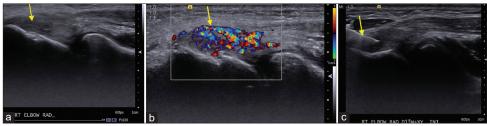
A 32-year-old male patient complaining of the right lateral elbow pain for approximately 1 month, (a) ultrasound showed uneven hypoechogenicity from the extensor digitorum tendon to the lateral epicondyle (arrow), (b) color Doppler ultrasound showed high blood flow (arrow), (c) the symptoms resolved after two injections of ultrasound-guided repeated puncture treatment combined with injection of 15% high-concentration dextrose solution (arrow)
